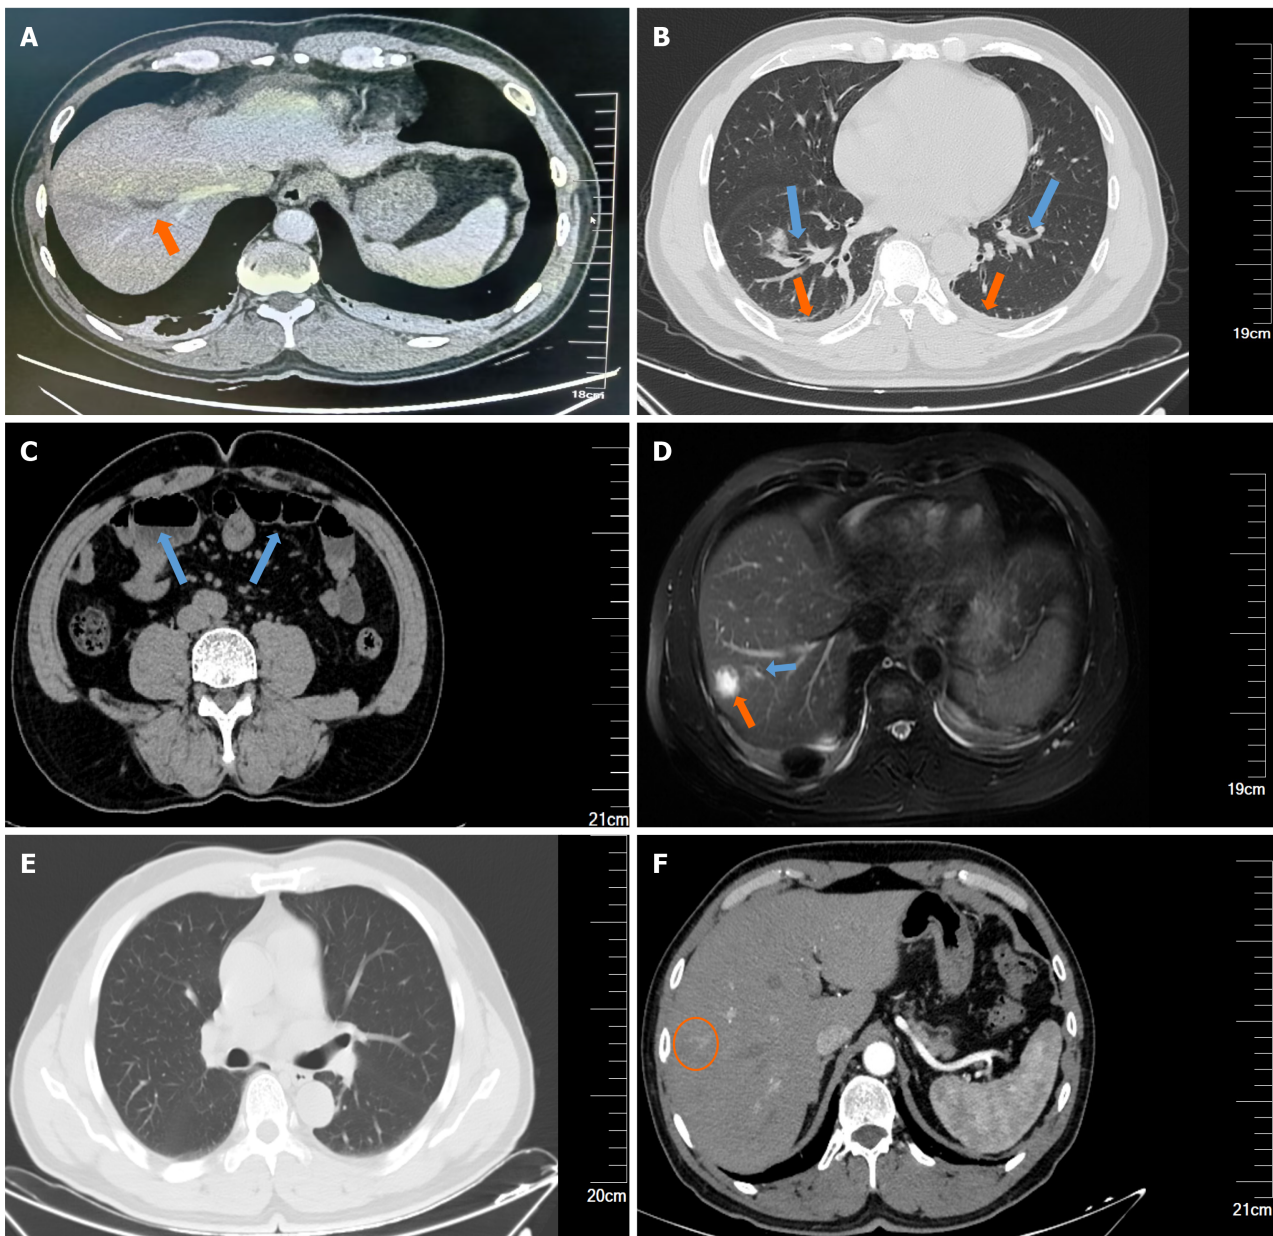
Imaging examination results of the patient. A: Hepatic enhanced computed tomography (CT) showed hepatic thrombophlebitis in the right liver lobe (orange arrow: Filling defect in the vein with irregular wall thickness); B: Abdominal CT showed bilateral lung inflammation (blue arrow) and bilateral pleural effusion (orange arrow); C: Intestinal CT showed fluid accumulation in the small intestine and bowel dilatation (blue arrow). During a 56-day follow-up; D: Magnetic resonance cholangiopancreatography showed a right liver lobe abscess and purulent cholangitis (orange arrow: 20 mm × 16 mm liver abscess; blue arrow: Purulent cholangitis with thickened duct walls); E: Abdominal CT showed absorbed pneumonia and pleural effusion; F: Hepatic enhanced CT revealed low-density nodule (approximately 6 mm) in the upper segment of the right lobe (S8) indicating granulomatous changes after liver abscess treatment (orange circle) and complete resolution of the hepatic vein thrombus.
